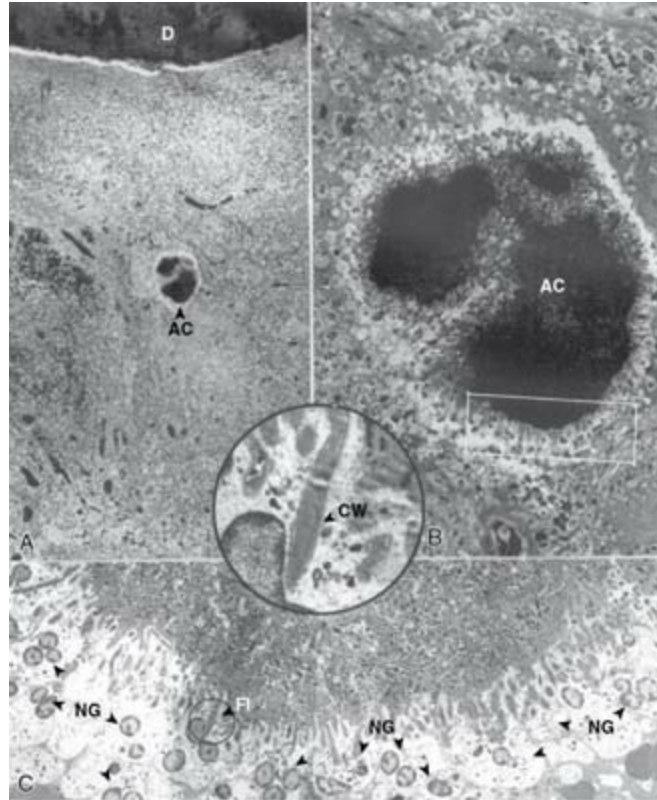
Actinomyces in the body of a human periapical granuloma. The actinomycotic colony (AC) in (A) is magnified in (B). The rectangular area demarcated in (B) is magnified in (C). Note the starburst appearance of the colony with needle-like peripheral filaments surrounded by few layers of neutrophilic granulocytes (NG), some of which contain phagocytosed bacteria. A dividing peripheral filament (FI) is magnified in the inset. Note the typical gram-positive wall cell wall (CW). D, Dentine. Original magnification: A, $\times 60$; B, $\times 430$; C, $\times 1680$; inset, $\times 6700$.
